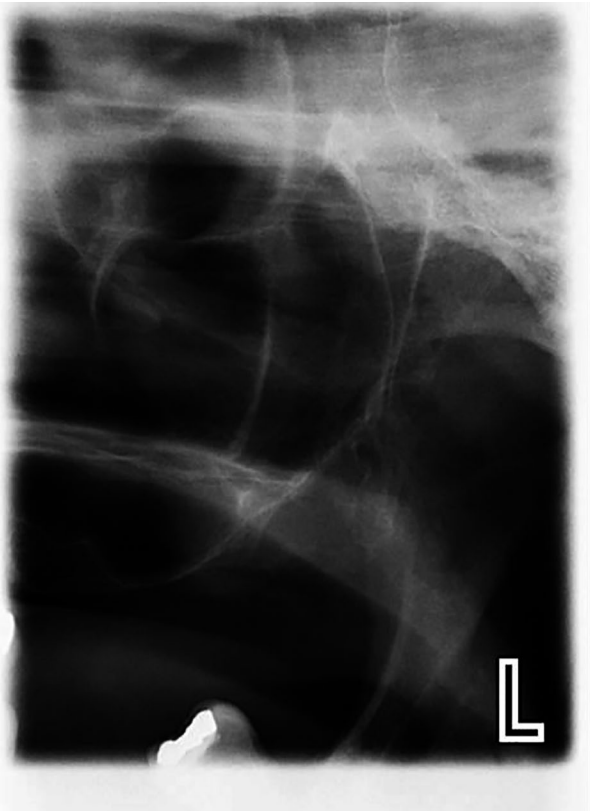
6 month post-operative radiographic review showed resolution of the cyst
